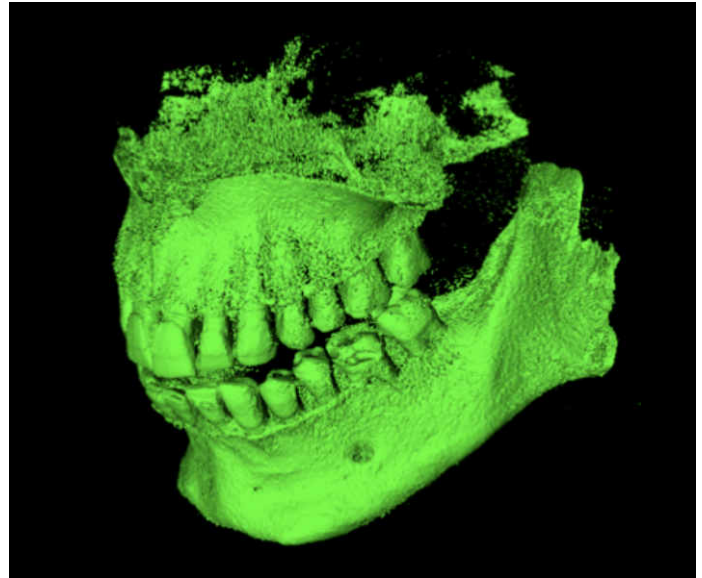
The reddened head area of the patient with upper jaw and lower jaw can be seen. The selected Hounsfield Unit area was set to 622 to 1988. With a larger range, other areas of the head would also be displayed, which would interfere with the diagnosis and contain no relevant information. If a smaller range is selected, parts of the bone structure are no longer displayed, as can be seen in Figure 11. The opening of the jaw due to the bite splint of the CBCT device is clearly visible. You can also see the prepared tooth 3-6 on the lower jaw.
